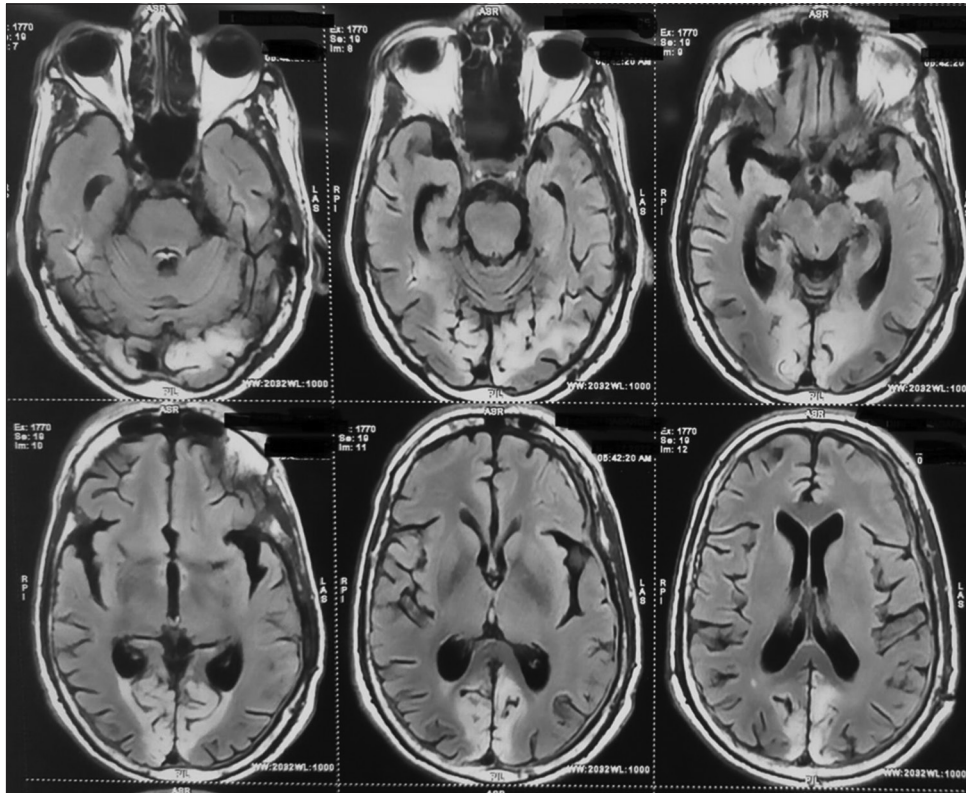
Magnetic resonance imaging brain shows T2 flair showing hyperintensities in B/L occipital region
